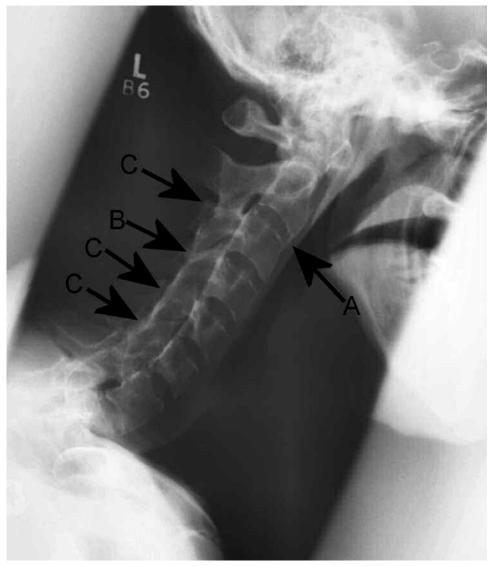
Lateral cervical spine radiograph in psoriatic arthritis. For the purposes of scoring, the syndesmophyte at C2/C3 (A) was scored as grade 3 for both vertebral corners. The other vertebral bodies do not show any abnormalities. The pair of facet joints at B were scored 0, whereas the facet pairs at the other levels (C) were scored 1. Total score for the cervical spine = 9.
